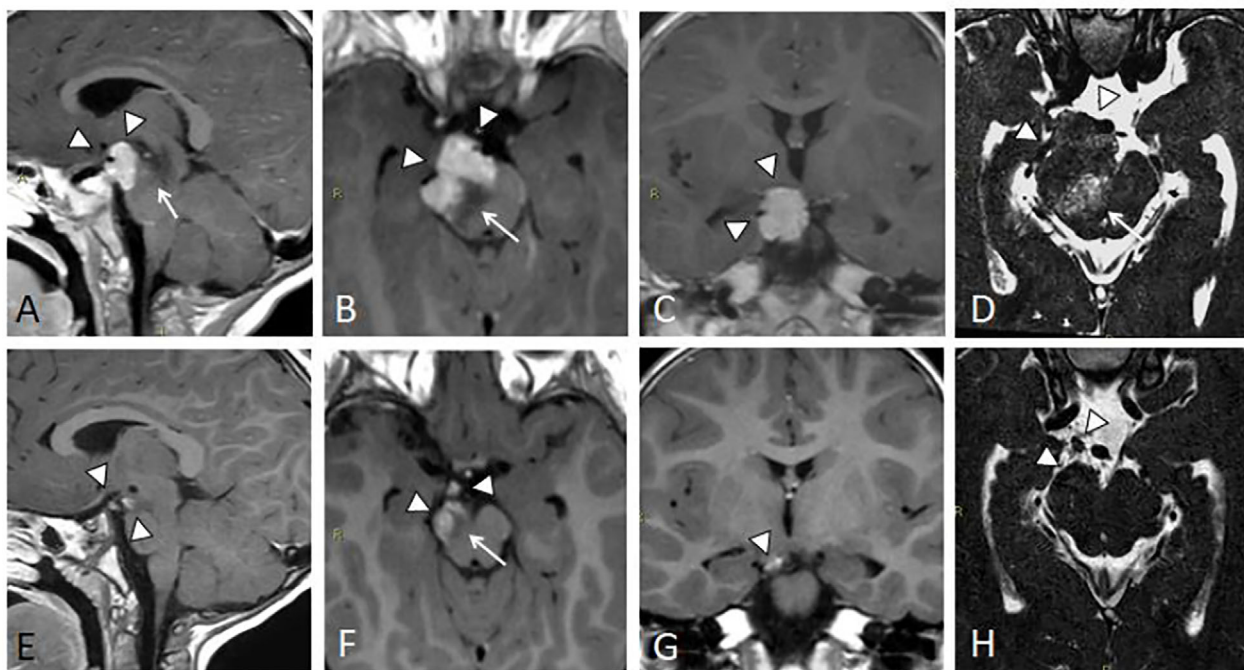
MRI of an infant with invasive clear-cell meningioma of the brainstem. Post-surgical/preprotontherapy MRI: (A–C) sagittal, axial, and coronal 3D T1-weighted multiplanar reconstructions (MPR); (D) axial 3D T2 DRIVE. Meningioma arising from the right third cranial nerve, infiltrating adjacent ventral portion of the mesencephalon (arrowheads); perilesional vasogenic edema is evident (arrow). (E–G) Postprotontherapy MRI, 39 months after treatment: sagittal, axial, and coronal 3D T1-weighted MPR; (H) axial 3D T2 DRIVE. Noticeable volume reduction of the treated meningioma (arrowhead) along with perilesional edema (arrow)
